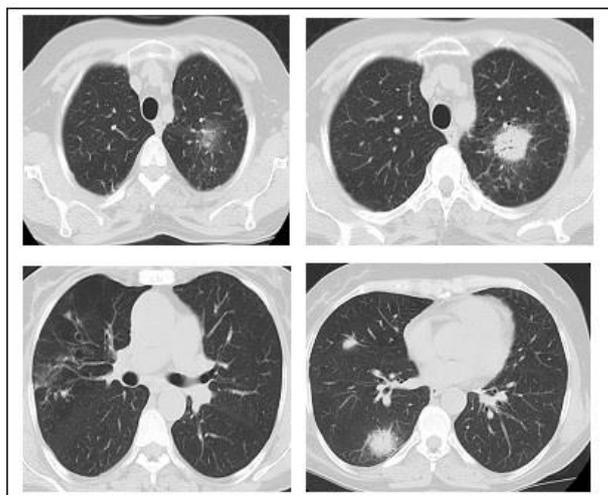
Computed tomographic scans of the chest showing dense consolidated areas in the right lower lobe and left upper lobe of the lungs
